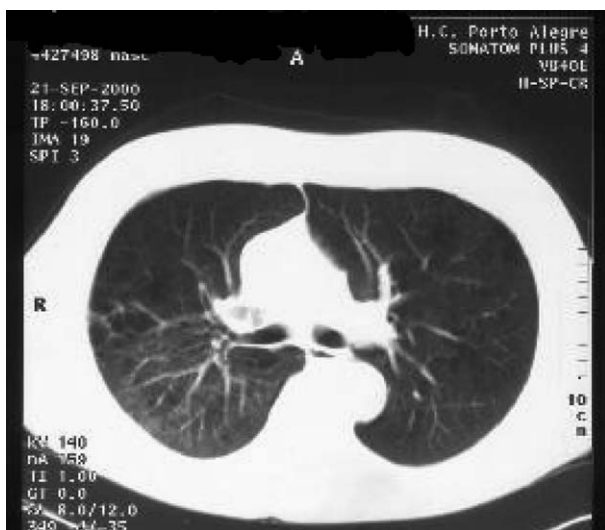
Thorax CT of patient 1 confirming the new consolidation in posterior segment of the superior right lobe.
